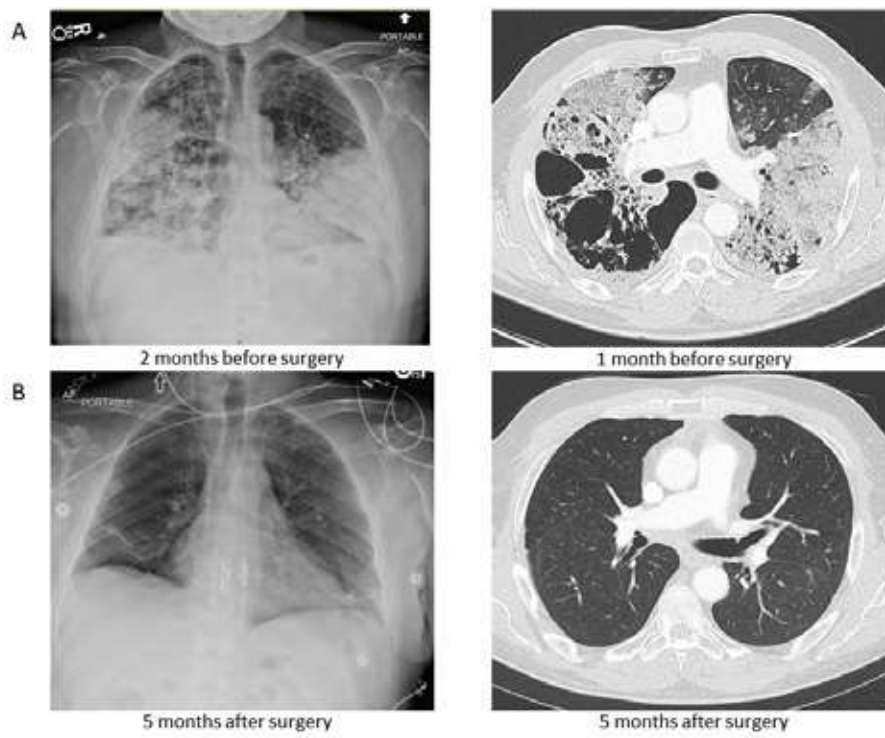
Chest X ray and CT scan before (A) and after (B) lung transplantation
